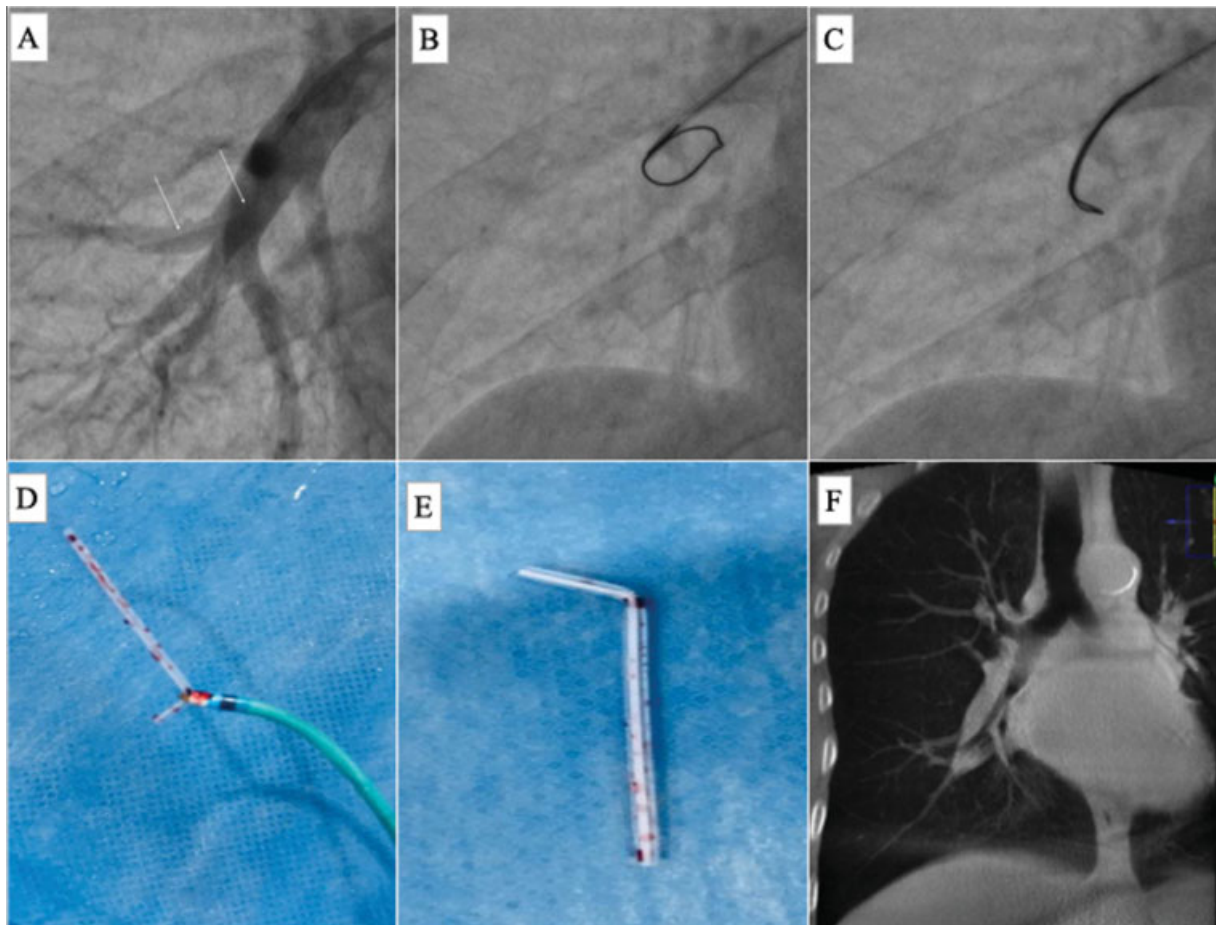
(A) Pulmonary angiographic spot image in posteroanterior (PA) projection localized the foreign body as a linear filling defect in segmental branch of right descending pulmonary artery (arrowheads) (B) Fluoroscopic spot image showing opened end of Amplatz gooseneck snare before deployment across the radiolucent foreign body (C) Engaged radiolucent cannula tip by the snare in the guiding catheter (D & E) Retrieved foreign body, i.e., fractured peripheral intravenous cannula tip (F) Check cone beam CT coronal reconstruction showing no residual foreign body in corresponding right pulmonary artery branch.
